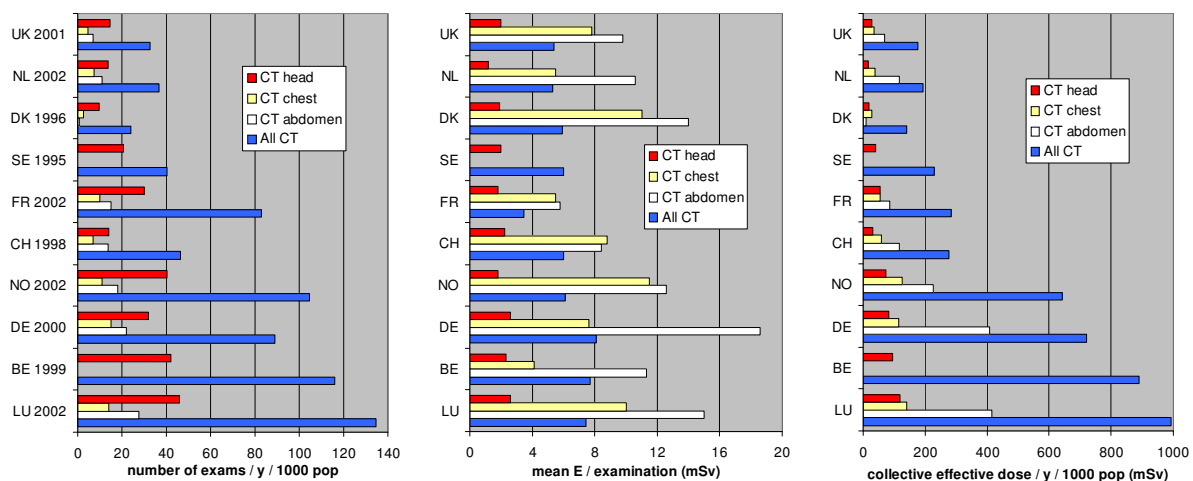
Frequency and dose data for three CT examinations and all CT in the ten DOSE DATAMED countries [DOSE DATAMED 2008]
